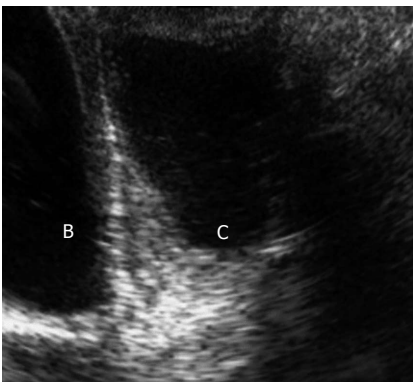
Pelvic ultrasound showing cyst separate from bladder. C: Cyst; B: Bladder.
